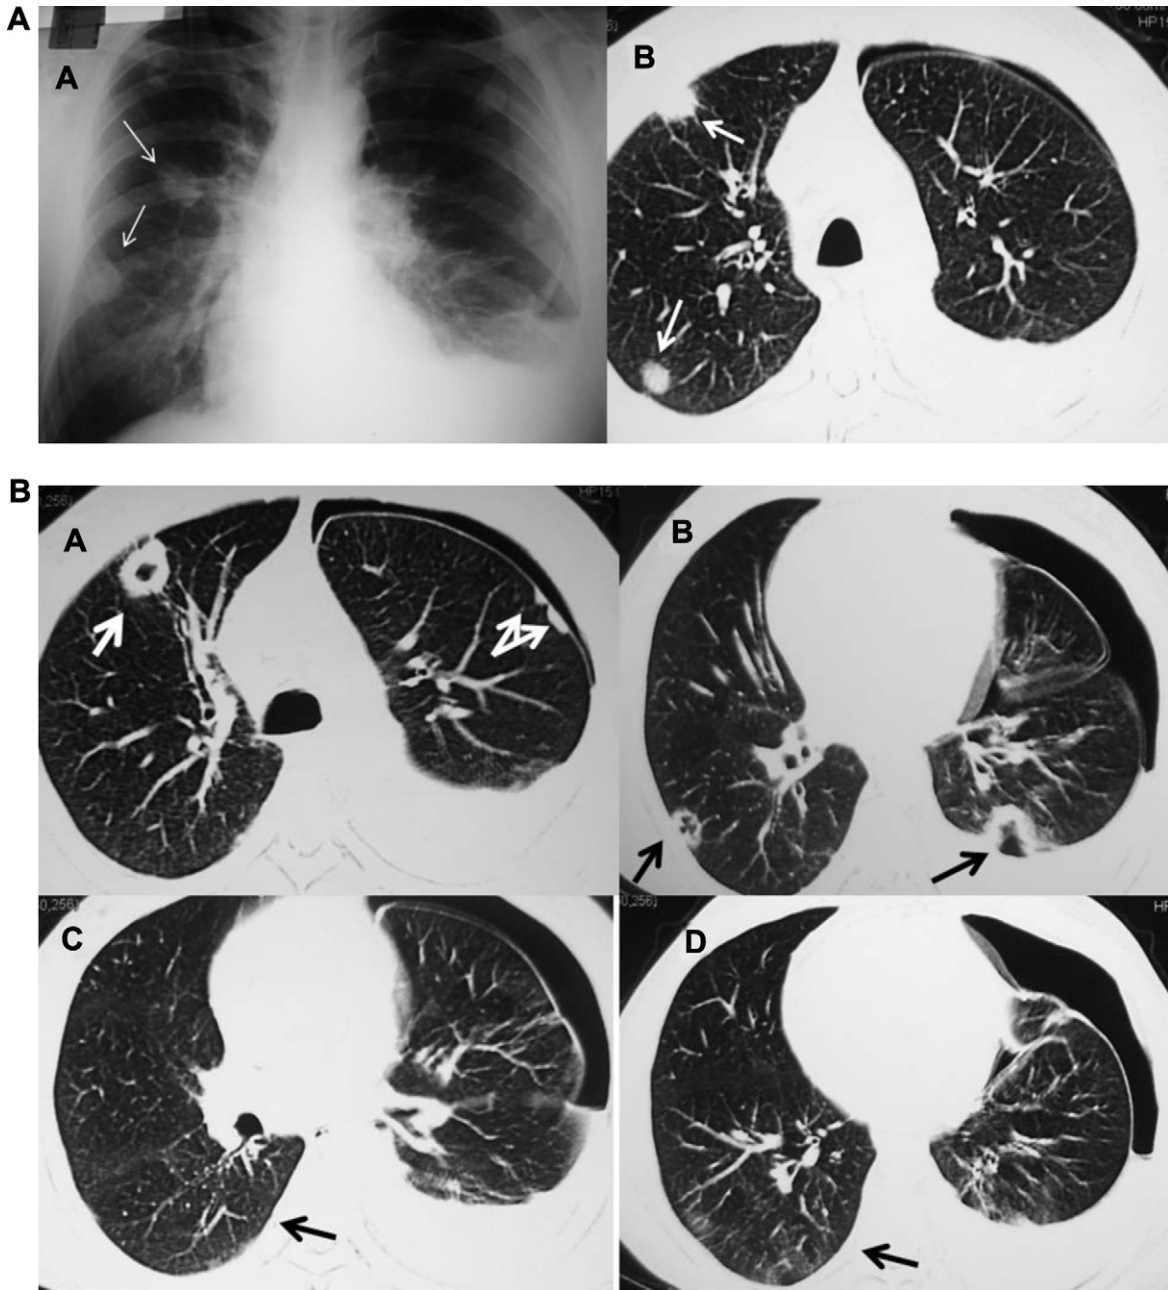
A and B (Patient 1): The forty six years old Turkish male patient was admitted to the hospital with dyspnea and cough.. There was five years history of seropositive RA. He had receiving immunosuppressive treatment for RA. The chest radiograph and thorax CT showed the bilateral nodular lesions and some of them were cavitate, pleural plaques on visceral pleura, mediastinal lymphadenopathy and hydropneumothorax. The cholesterol levels of first patient were very high (424 mg/ml) in the pleural effusion and this defines to be the pseudochylothorax.
